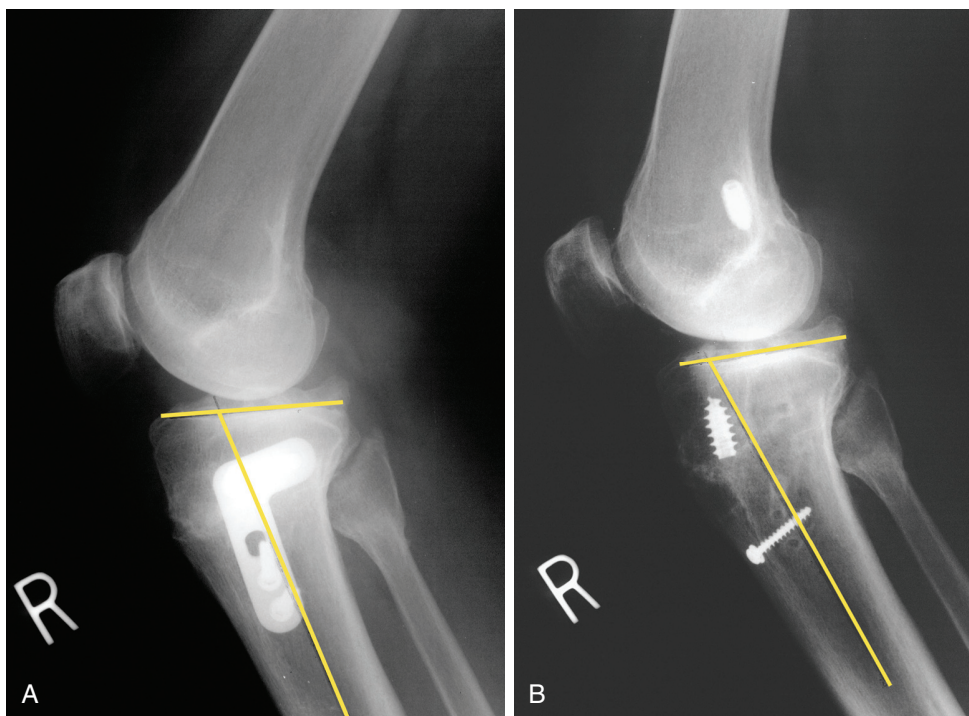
Radiographs of a 52-year-old physician referred for treatment after a closing wedge osteotomy (A) and subsequent anterior cruciate ligament (ACL) bone-patellar tendon-bone autograft (B) that failed. It would have been desirable to correct the abnormal tibial slope, which may have been a factor in the ACL graft failure.
